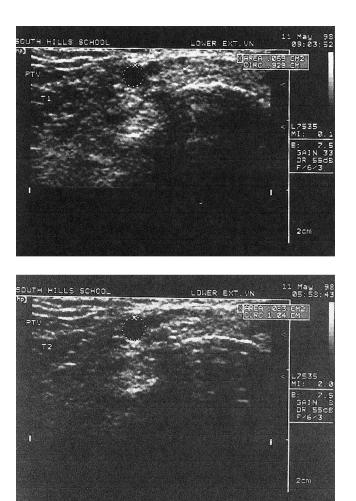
Upper panel, example sonographic view of the posterior knee, locating the popliteal vein (POP). This subject's vein (traced) is located superficial to the artery (right and inferior). The tracing of the vein produces the area calculation for trial 1 pre-8 h of standing. Lower panel, the identical view of the left bifurcation of the PTV was traced for trial 2 at the end of the day after standing for 8 h with the area calculation produced.
